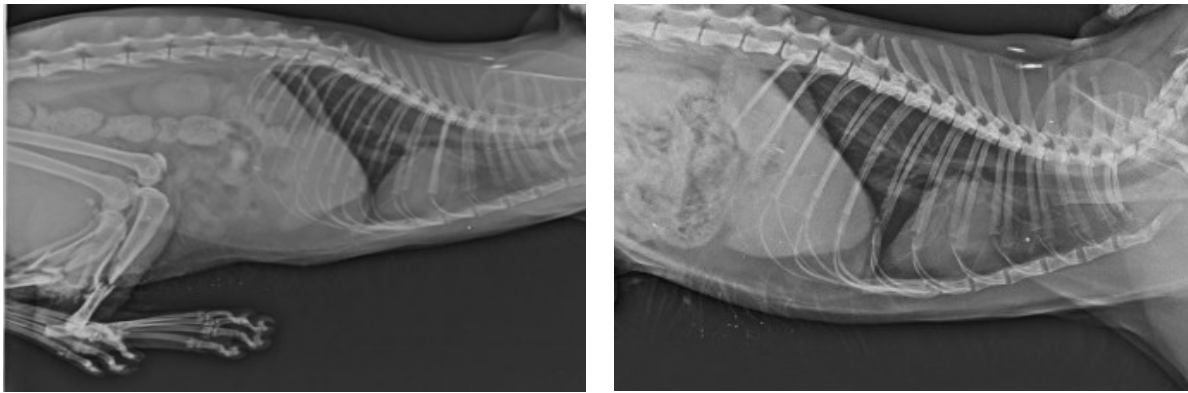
Images from the 3rd day of the trauma; A: Pleural effusion cranial to the heart on the thoracic radiograph (L-R laterolateral view). C: post-treatment thoracic radiograph in Gil (L-R laterolateral view). A significant decrease in the effusion is striking.
